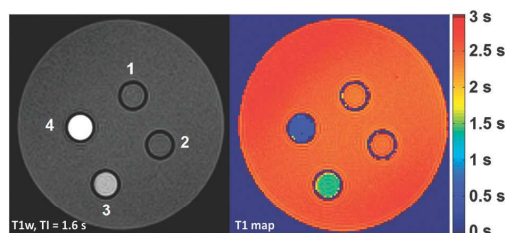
MR images of 4 different solutions: 1. 4 (2 mM in water), 2. water, 3. water + 20% piperidine and 4. 4 (2 mM in water + 20% piperidine). For details see ESI.†
